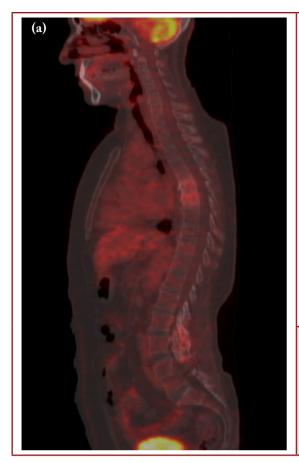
a, b. FDG PET-CT: increased FDG uptake in the T5-T7 vertebrae and the discs before treatment.
